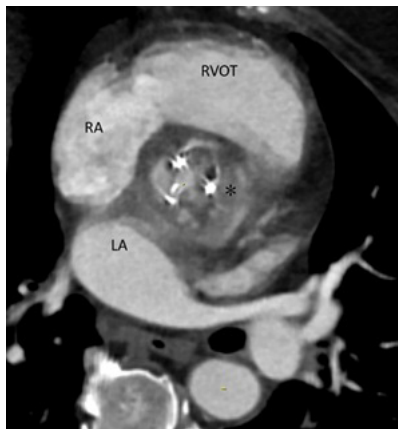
Chest CTA (short axis view) with abnormal parietal thickening of the aortic root (*). LA - left atrium; RA - right atrium; RVOT - right ventricular outflow tract.
